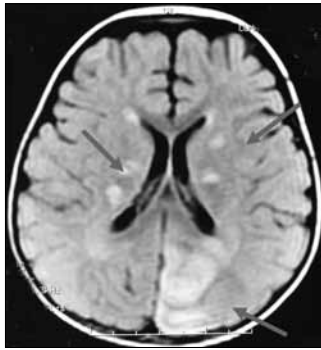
Posterior leukoencephalopathy syndrome in a GBS recipient who was taking IVIg (patient 2). Axial magnetic resonance image shows abnormal signal intensity in bilateral basal ganglia and right occipital lobe
